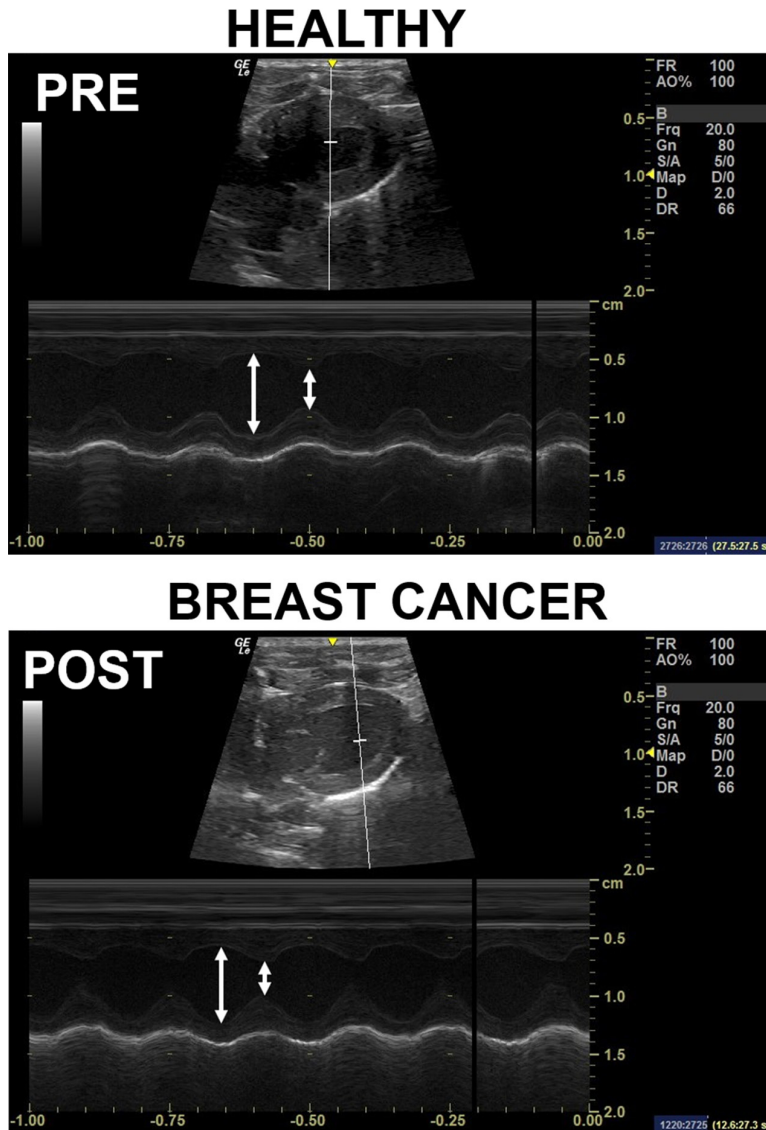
Representative images of pre- and post-breast cancer echocardiography measurements. No changes were seen in cardiac function over time (~25 days between measurements). Arrows represent the LV during diastole (widened 1st arrow) and during systole (narrow 2nd arrow).
